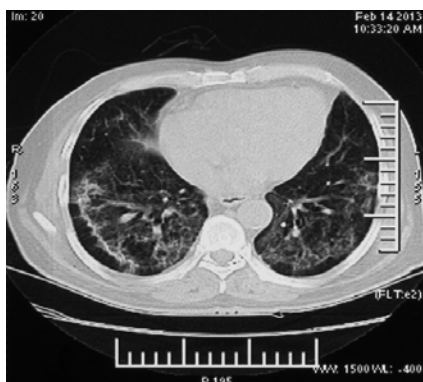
Chest CT-scan of patient.
